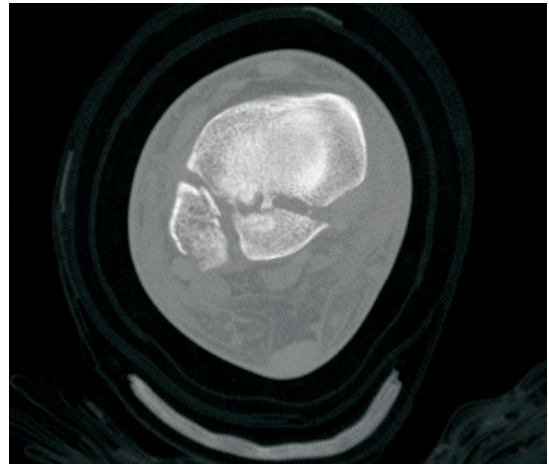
Axial computed tomography image of a bimalleolar equivalent ankle fracture demonstrates a large posterior malleolar fracture with small intraarticular fracture fragments.
